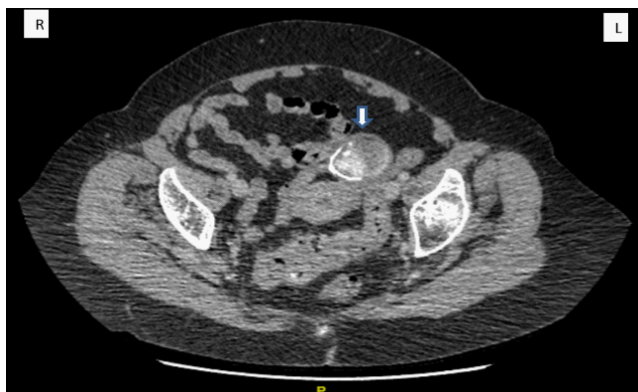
Axial view CT Pelvis with contrast showing left calcified adnexal mass.
